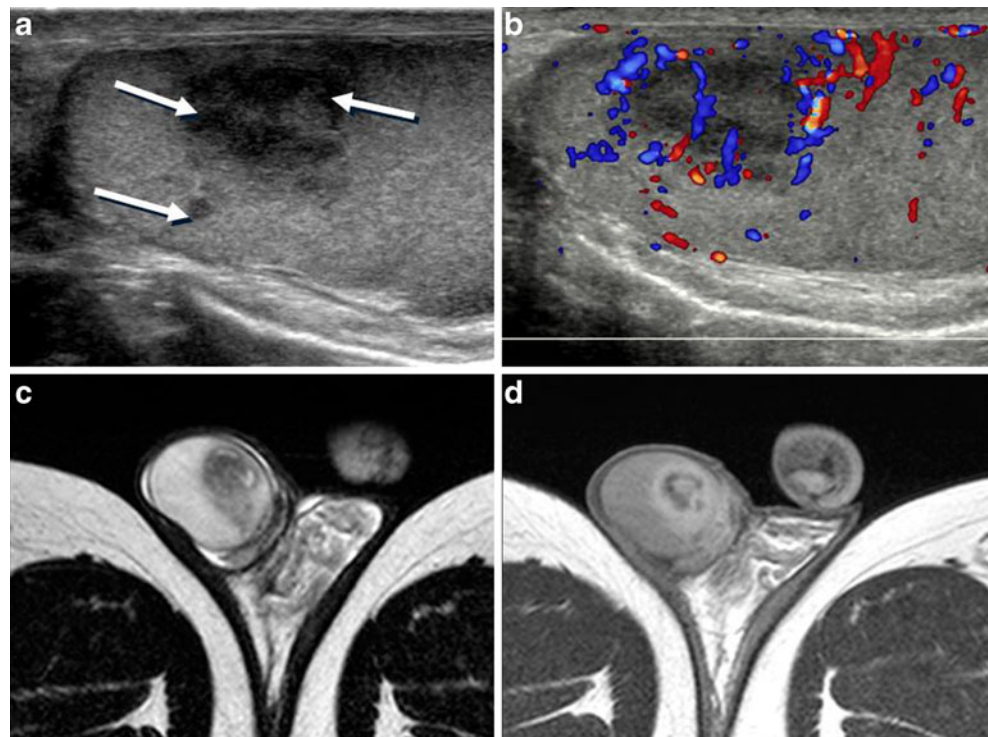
A 44-year-old man with isolated testicular tuberculosis and abscess formation of the right testis. a Longitudinal US of the right testis shows heterogeneous ill-defined hypoechoic lesions (arrows). b Colour Doppler US shows increased peripheral vascularity. c T2-weighted MRI shows heterogeneous low signal intensity lesion within the right testis. d Enhanced T1-weighted MRI shows peripheral strong enhancement. Radiologic primary diagnosis was testicular cancer. The radical orchiectomy was performed. The pathologic results indicated testicular tuberculous abscess without epididymal involvement
